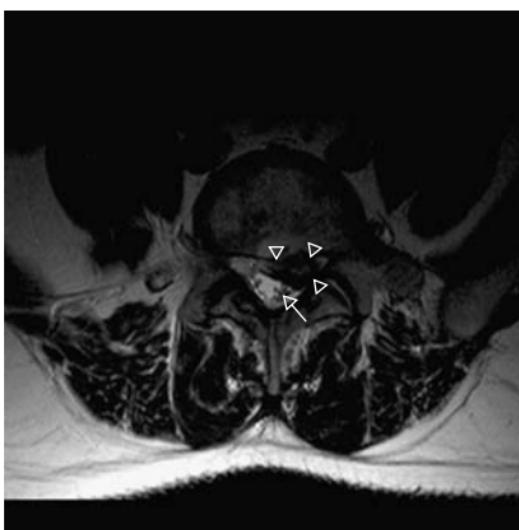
Lumbar disc protrusion. (a) Sagittal T2W and (b) axial T2W MRI. A large cranially migrating left paracentral disc protrusion ((a) closed white arrow; (b) open white arrowheads) is shown at the L4/5 level. Although the left lateral aspect of the theca is effaced and the forming left L5 nerve is compromised as it exits the theca, the intrathecal nerves in the cauda equina (white arrow) are not compressed. The migrating discal component is extradural, elevating and posteriorly compressing the dura ((a) black arrowheads). Note the small annular fissure in the L2/3 intervertebral disc ((a) black arrow).
